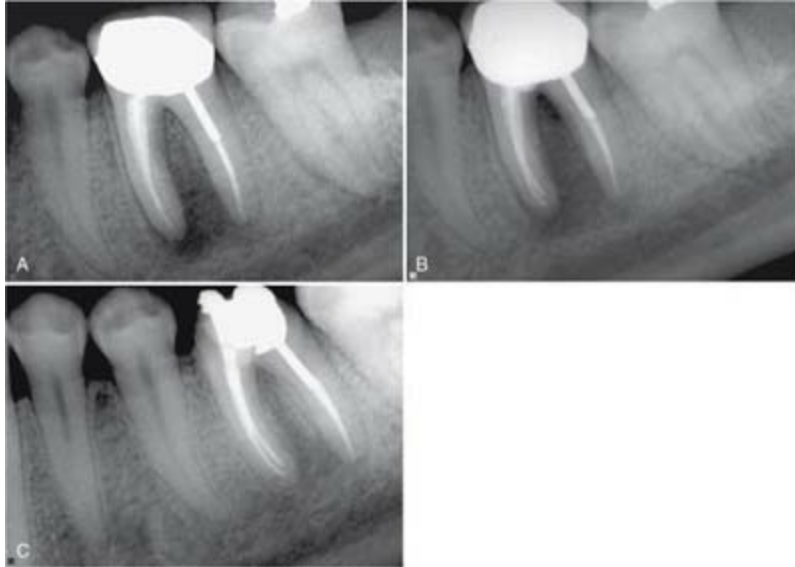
Despite several exacerbations during endodontic retreatment, this case responded rapidly after the completion of therapy. Radiographic evaluation indicates a good periapical response after only 4 months. A, Radiograph taken 2 years after initial root canal therapy. B, Retreatment of the mesial root. C, Radiograph taken 4 months following retreatment.
